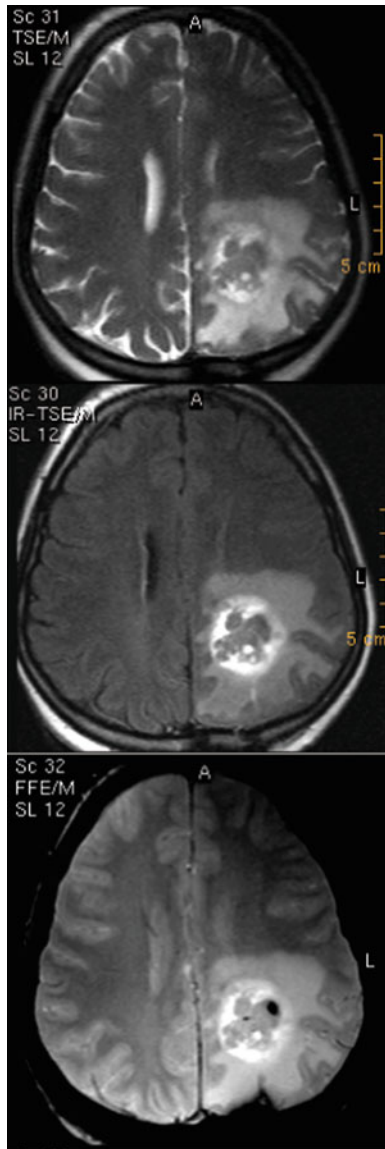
Following the brain biopsy, a series of three axial scans (half-Fourier acquisition single-shot turbo spin echo (HASTE) (*top*), turbo fluid-attenuated inversion recovery (FLAIR) (*middle*), and gradient echo (GE)-T2* (*bottom*)) are reviewed to exclude the presence of intraoperative hemorrhage before the conversion of intracellular oxyhemoglobin to deoxyhemoglobin has occurred. An area of signal loss in the same location on all three scans would indicate the presence of air
